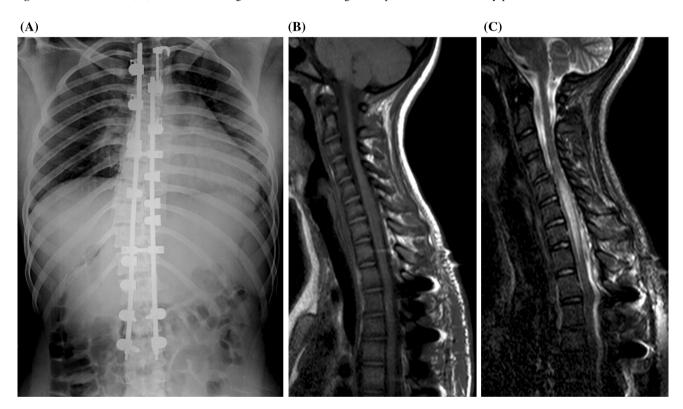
a Antero-posterior X-ray: severe scoliosis treated by metallic distractor. b, c T1- and STIR-weighted sagittal sections: C5-D1 spinal cord swelling with T2-w hyperintense signal related to medullary ischemia
